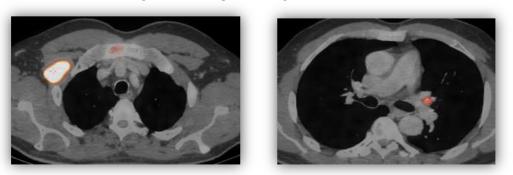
c: Axial PET/CT fused image of the upper chest. Fig. 4d: Axial PET/CT fused image of mid chest.
